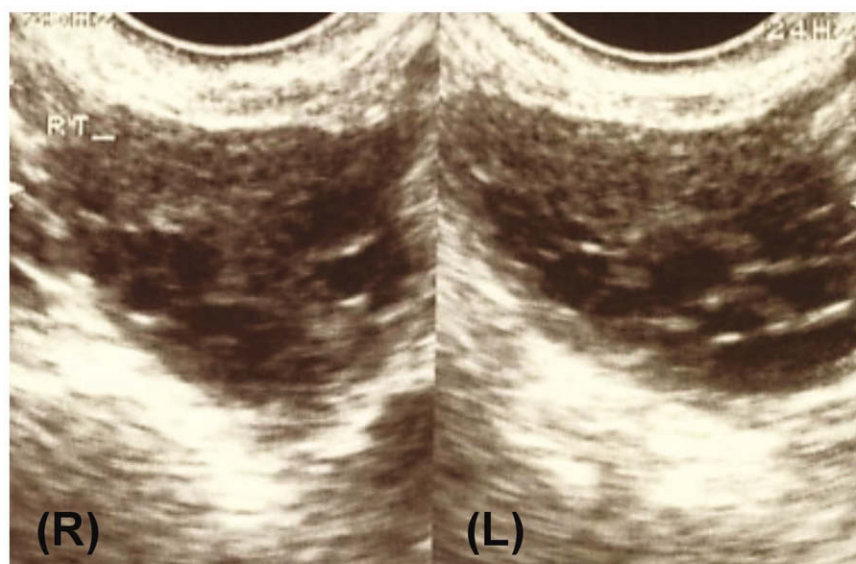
Transvaginal ultrasound view of polycystic ovaries in patient with polycystic ovarian syndrome. In total, 63 immature oocytes were retrieved from this patient at oocyte collection 36 h after HCG priming. The patient became pregnant and delivered a healthy male infant (see Chian *et al.*, 2001). (R): right-side ovary; (L): left-side ovary.
